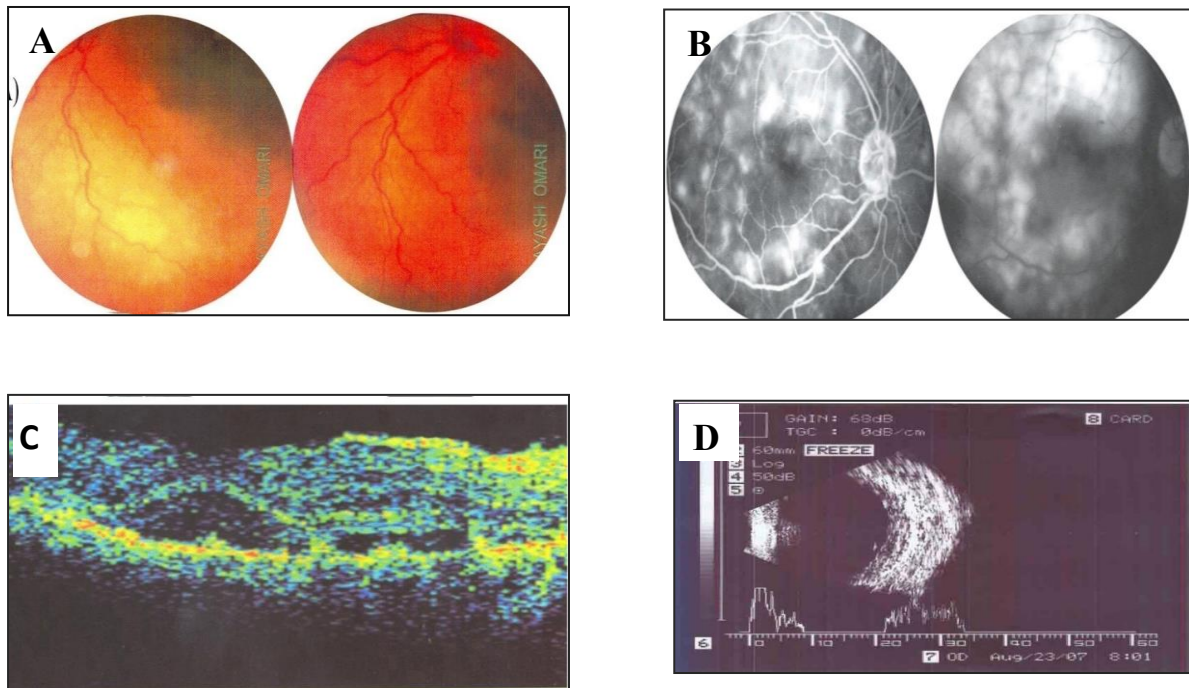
Initial examination of the right eye in case three (A) Color fundus images, (B) Fluorescence angiography, (C) O.C.T, and (D) ultrasonography
